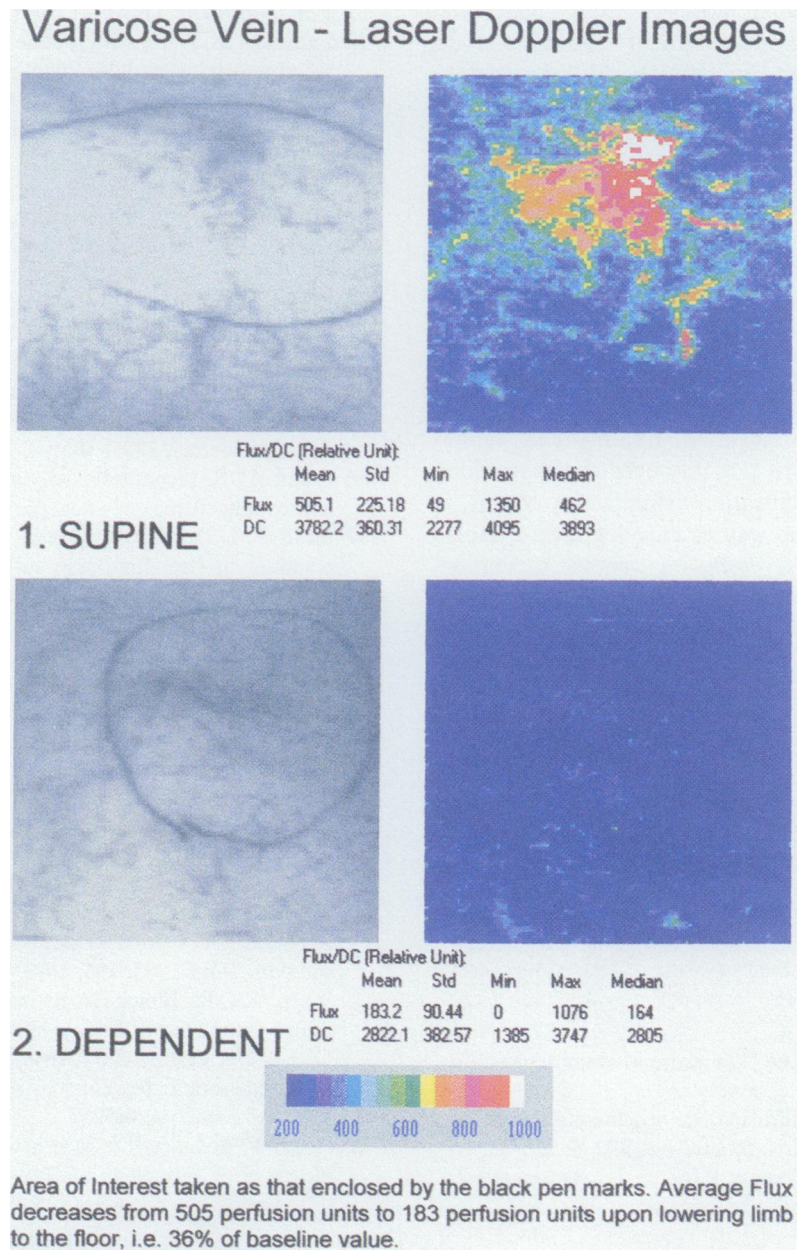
Note the paradoxical reduction of the laser Doppler flux over the site of the perforating veins marked by black pen. Average flux decreases from 505 perfusion units to 183 upon lowering limb to floor. (Courtesy Moor Instruments Limited and the Editor of the British Journal of Surgery 1998; 85: 1721).
